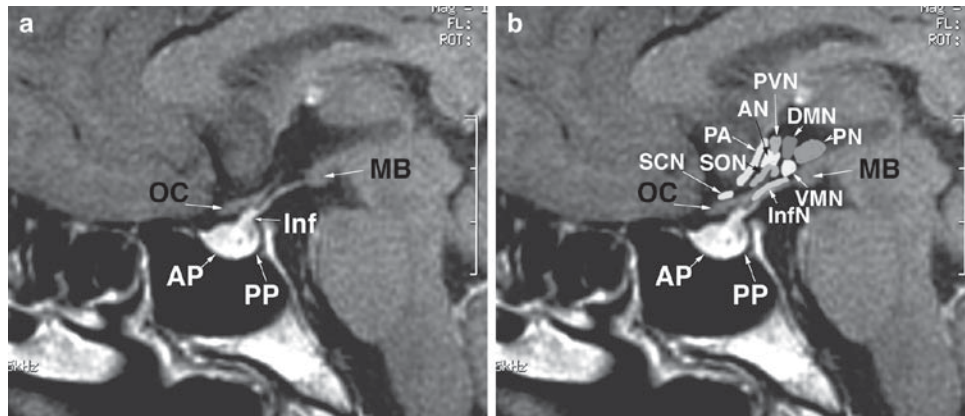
(a) Magnetic resonance imaging (MRI) of the brain of a normal subject, and (b) the approximate positions of the hypothalamic nuclei. OC optic chiasma; AP anterior pituitary lobe (adenohypophysis); PP posterior pituitary lobe; Inf infundibulum; MB mammillary body; SCN suprachiasmatic nucleus; AN anterior nucleus; PA preoptic
